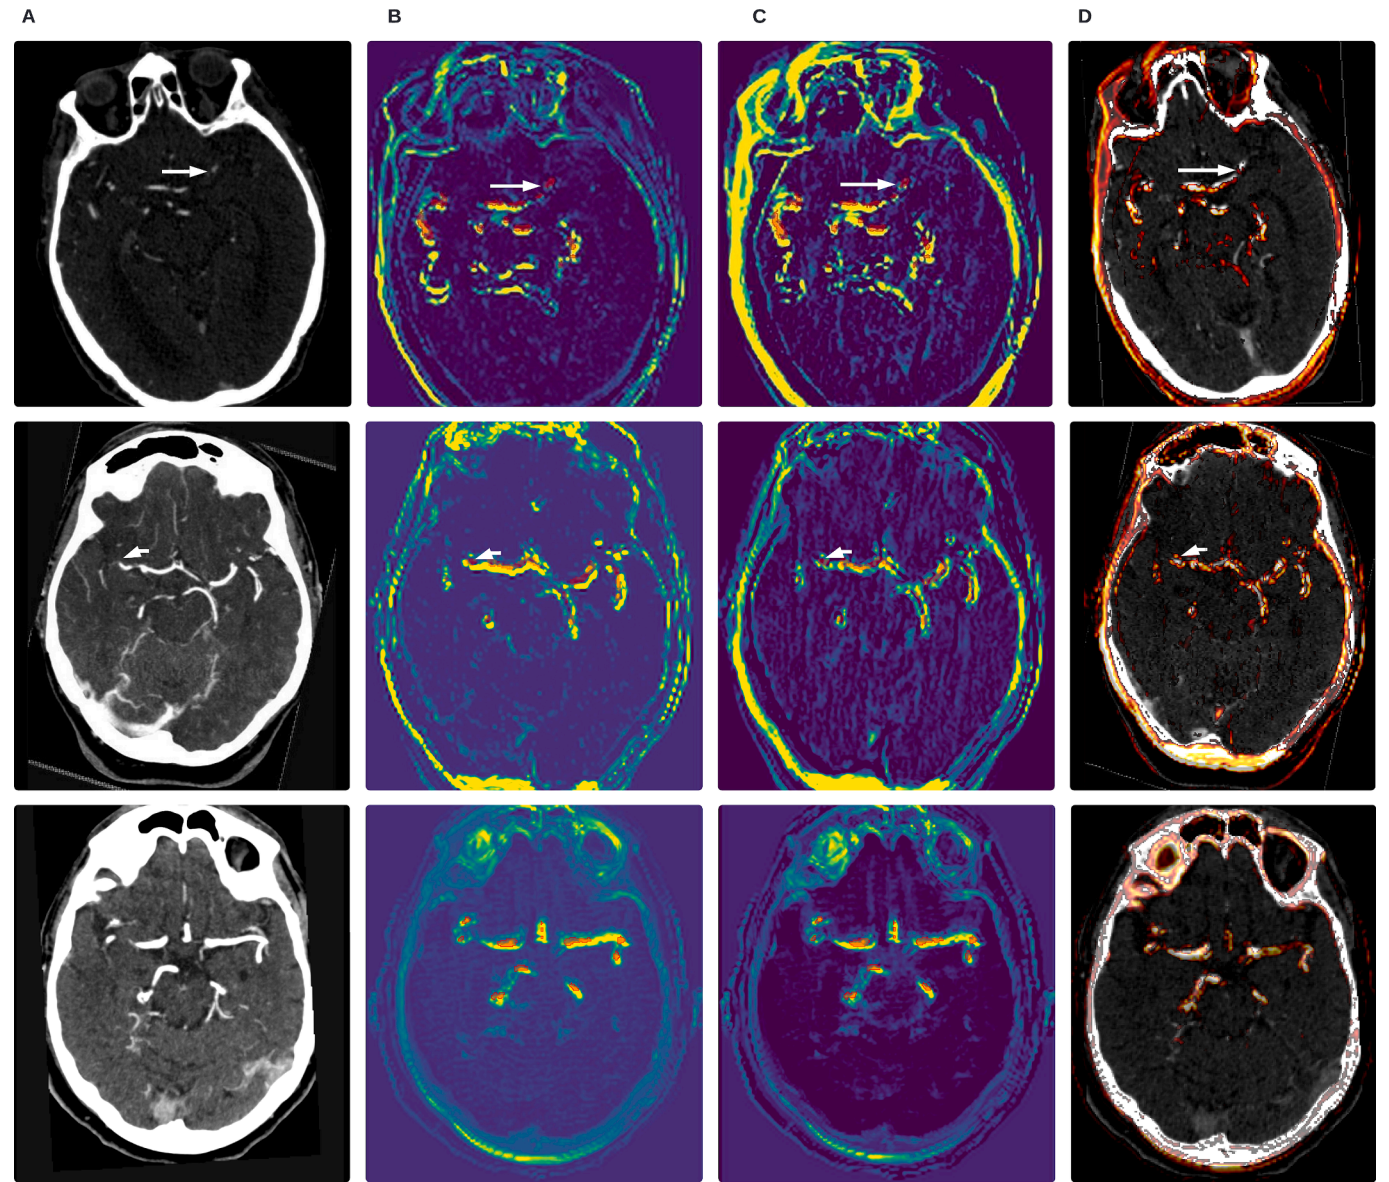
Saliency Map Analysis Highlighting the Effects of the DAFT Block on Feature Maps. Column A: CTA images pointing to a diagnosed occlusion. Column B: GradCAM before DAFT, with intensity visualized using the viridis color code. Column C: GradCAM after DAFT, with intensity also visualized using the viridis color code. Column D: Overlay of saliency maps on CTA image highlighting the focus on vessel walls. In Columns B and C, red indicates the vessel segmentation. Files 1 and 2 are true positives while file 3 is a false positive case.
